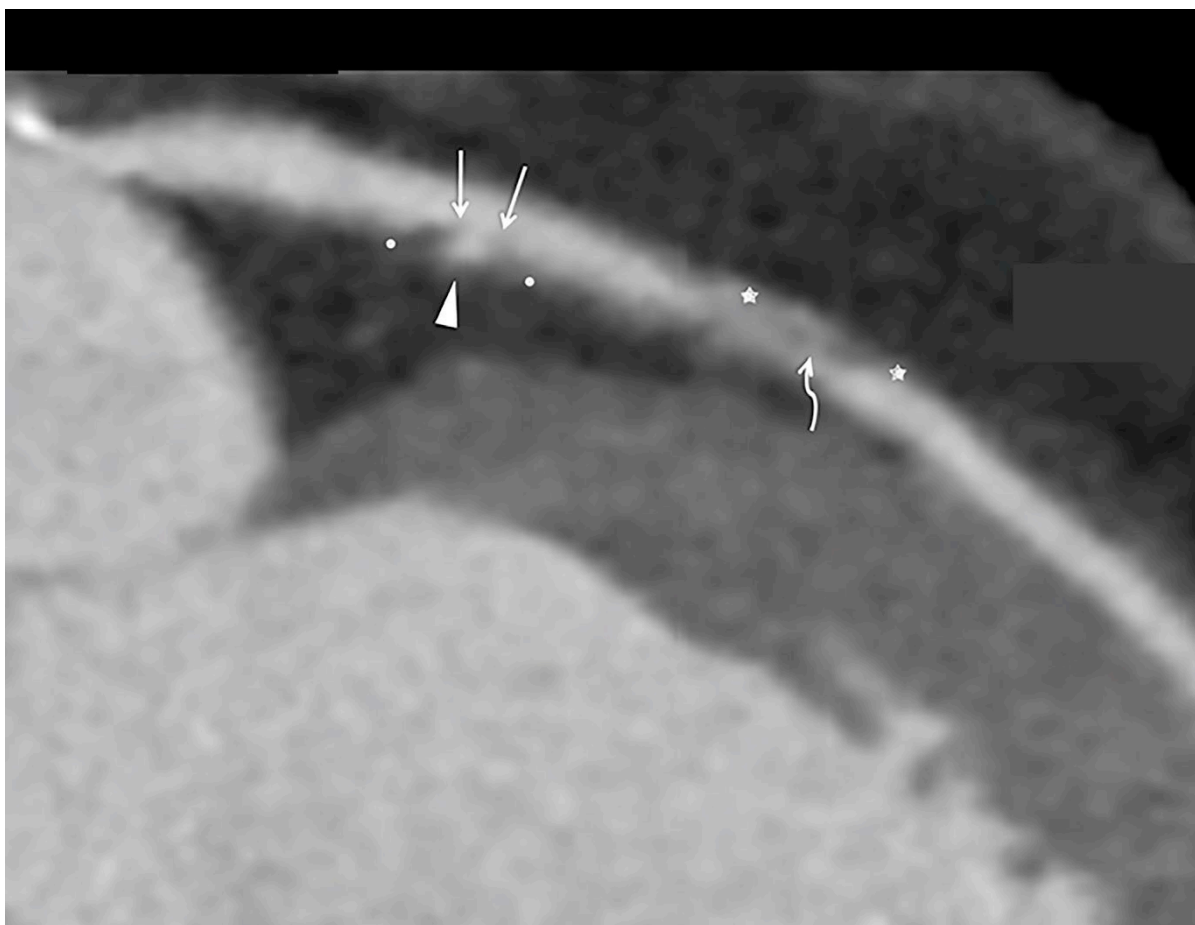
An eccentric ruptured plaque is seen along the inferior wall of the LAD marked by white dots. The straight arrows show the central ulceration on the plaque luminal surface. The arrowhead marks the cavity within the plaque filled with intraluminal contrast. Another plaque is seen marked by stars in the anterior wall of the LAD. This shows an ulceration along the inferior shoulder (curved arrow). Patient was scanned on a uCT 780 (United Imaging Healthcare, Shanghai, China) 160 slice cardiac CT scanner.
